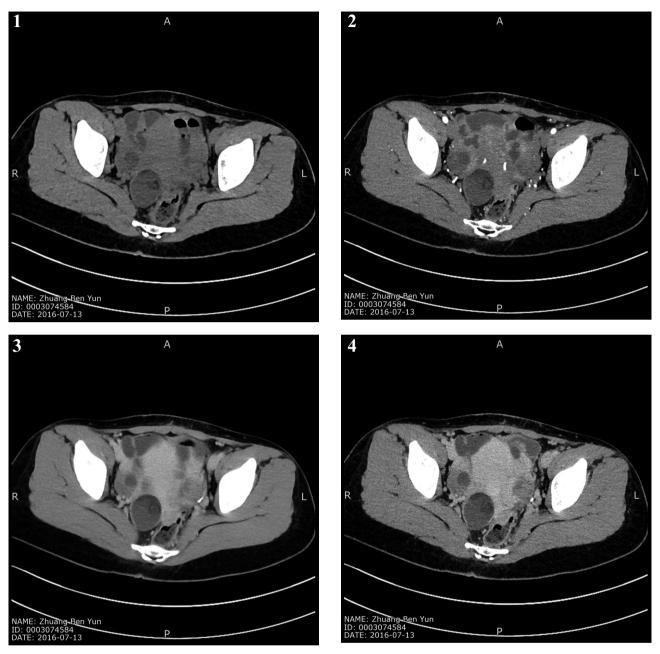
CT plain scan. The ellipse-like mass with mixed densities is visualized on the right side of the uterine rectum fossa (indicated by the black arrow); a signal of small nodular fat density is detected in the middle of mass (indicated by a white arrow). Figures 2–4. — CT enhancement scan. There is no obvious enhanced signal within the lesion during the enhanced arterial phase, venous phase, or delayed phase (indicated by a black arrow).
